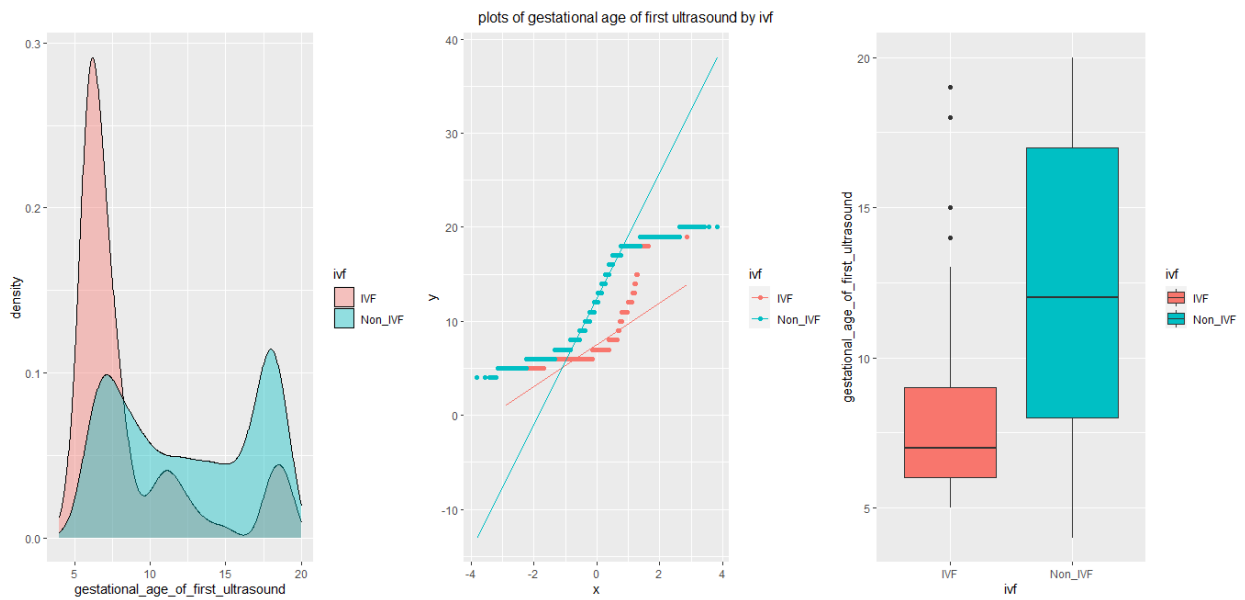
Density plot (left), Q-Q plot (center), and box plot (right) of the gestational age for the first ultrasound.
